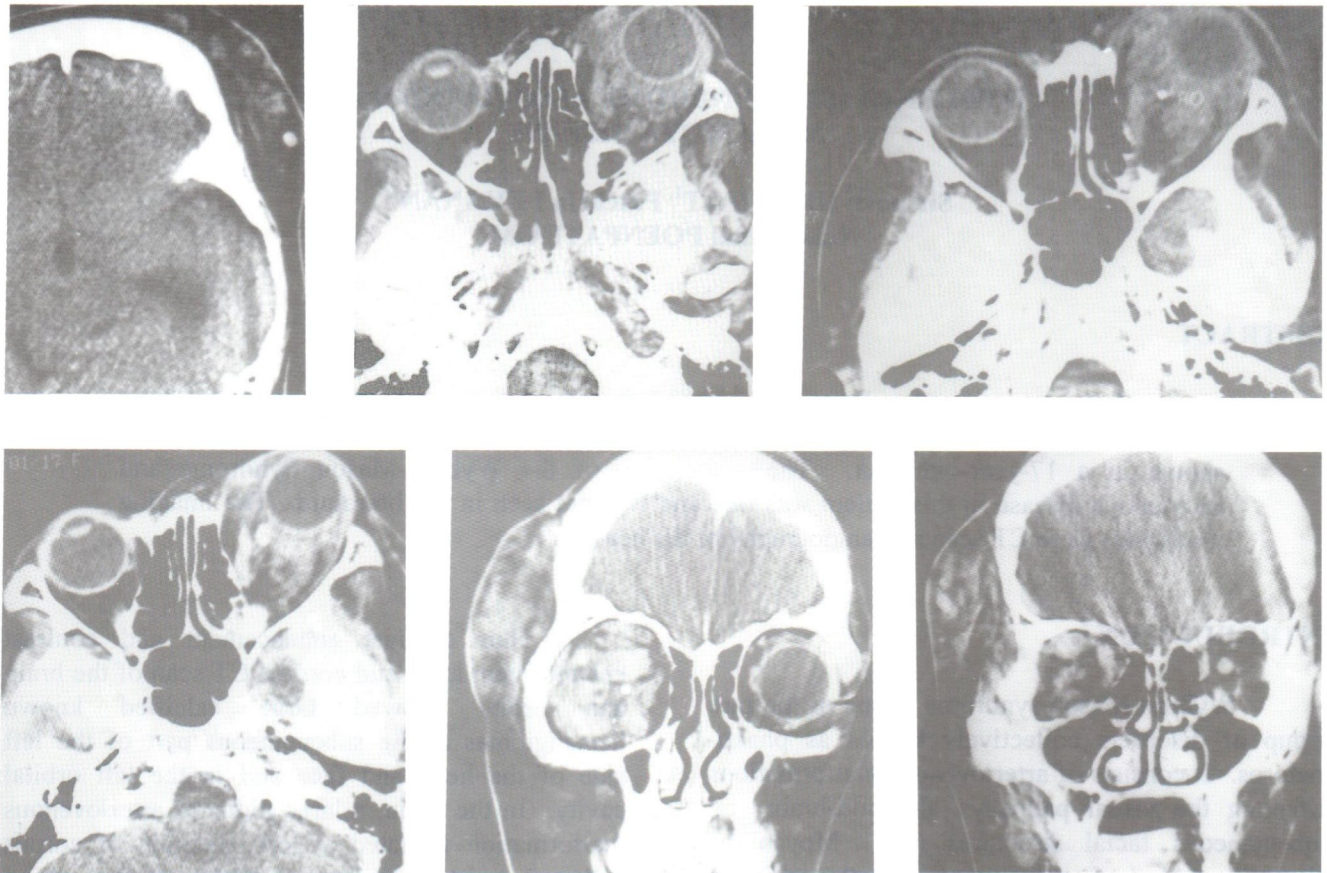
Axial nonenhanced CT scan of the orbits and enhanced coronal CT scan of the orbits showed the lesion of known hemangioma in the left orbital cavity, subcutaneous plane of left side of the head. Small calcification was noted in the lesions of both sites was shown.
